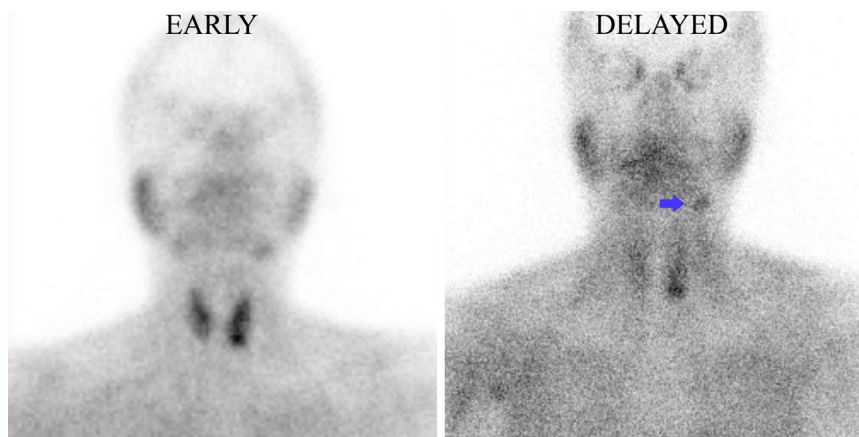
Dual-phase ^{99m}Tc -sestamibi scintigraphy of a patient with raised serum parathyroid level showed differential tracer washout at the lower pole of the left thyroid lobe indicative of a left inferior parathyroid adenoma. There is another focus of uptake in the left submandibular region (arrow) on the delayed image, which correlates to uptake in the left submandibular gland on the early image. Thus, asymmetric tracer activity in the submandibular glands can lead to false-positive interpretation.
